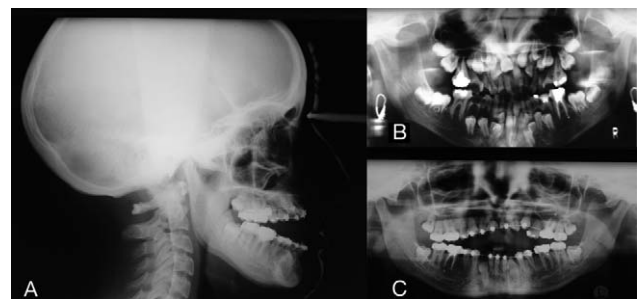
Case 8. (A) Profile teleradiography showing a typical anterior open bite and a class III malocclusion with a retruded and hypoplastic maxillary bone. (B and C) Panoramic x-rays before and during orthodontic treatment.
